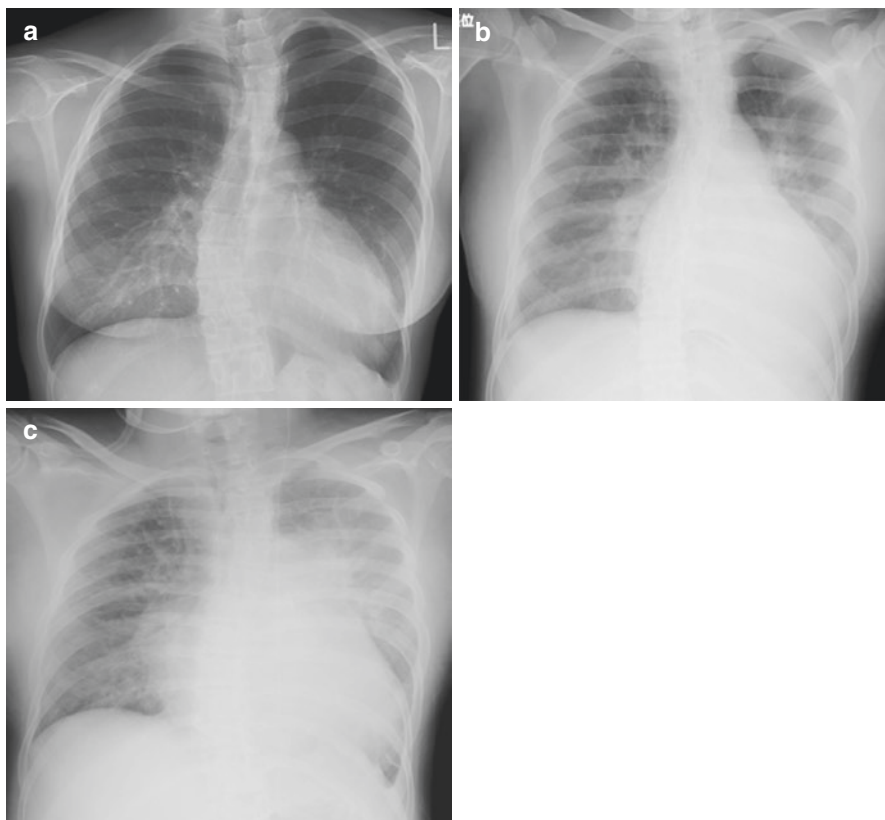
The clinical course of a twin pregnancy in a woman after Jatene operation. She was in NYHA class II before pregnancy and had a twin pregnancy. She had several atrial and ventricular arrhythmic events during pregnancy. Her plasma brain natriuretic peptide (BNP) levels were around 50 pg/mL before and during the first half of pregnancy and then elevated more than 150 pg/mL at 32 weeks of gestation. At the same time, she started to complain of shortness of breath. Her twin babies were diagnosed as intrauterine growth arrest, and she delivered by Caesarean section at 34 weeks of gestation. Her chest X-ray changed from 26 weeks of gestation (a) to 33 weeks of gestation (b) and 6 hours after delivery (c). She was given intravenous administration of diuretics, and her pulmonary edema was resolved
